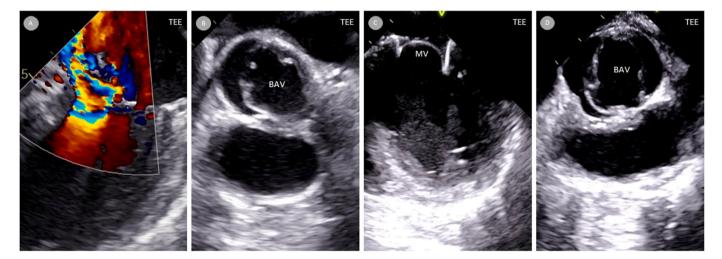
TEE immediately before surgery: severe MV regurgitation in color doppler imaging, BAV without vegetation (A and B) and 6 months after surgery: MV bioprosthesis and BAV without vegetations (C and D).
